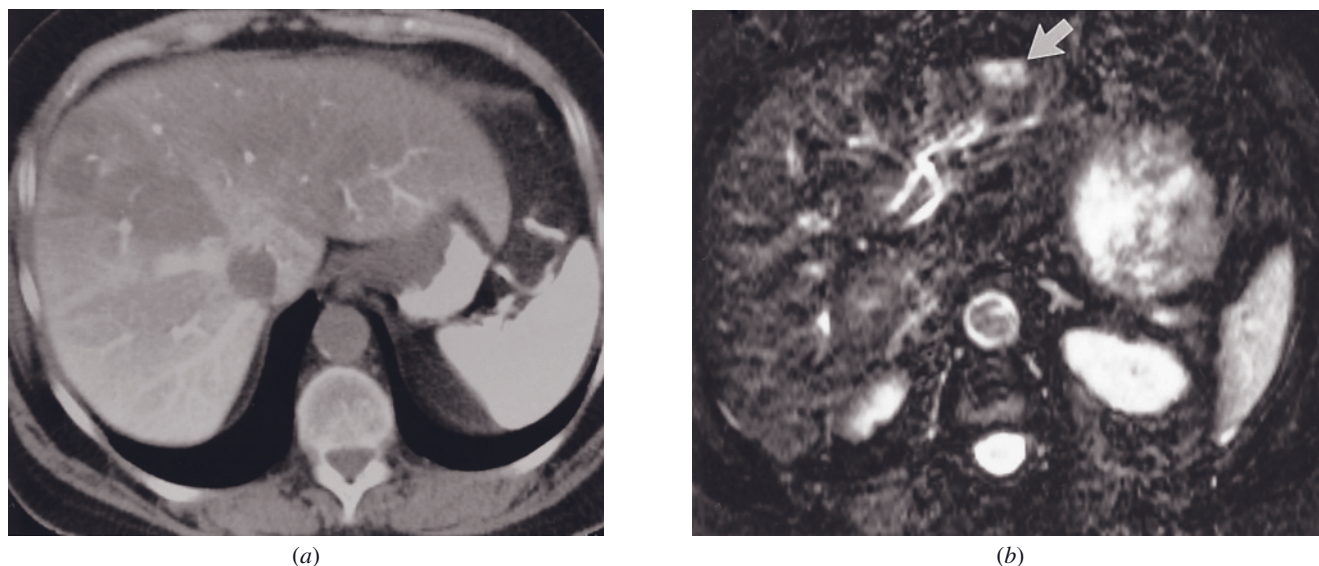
Liver metastases—perfusional defect. Spiral CTAP (a) and fat-suppressed T2-weighted SS-ETSE (b) images. Multiple large perfusional defects are present on the CTAP image (a), with the entire left lobe exhibiting diminished perfusion. A 1.5-cm liver metastasis is present on the T2-weighted image (arrow, b), which was masked by the perfusion defect on the CTAP image.
